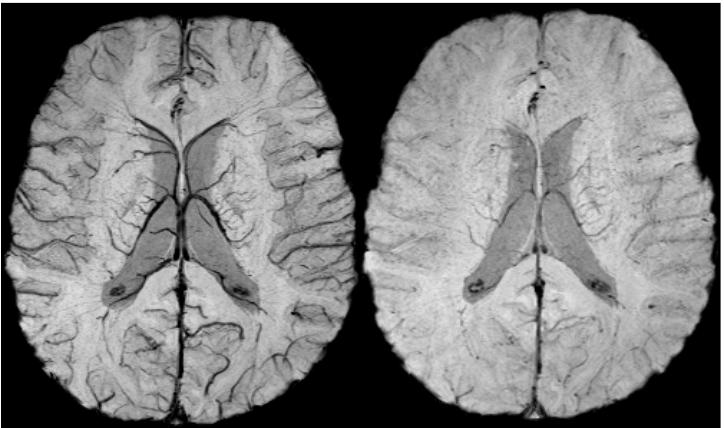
Minimal intensity projection of 16 mm thick 3D SWI data of a 7 year old patient at two different MRI exams. The patient was under general anesthesia. Images were generated with identical parameters.
